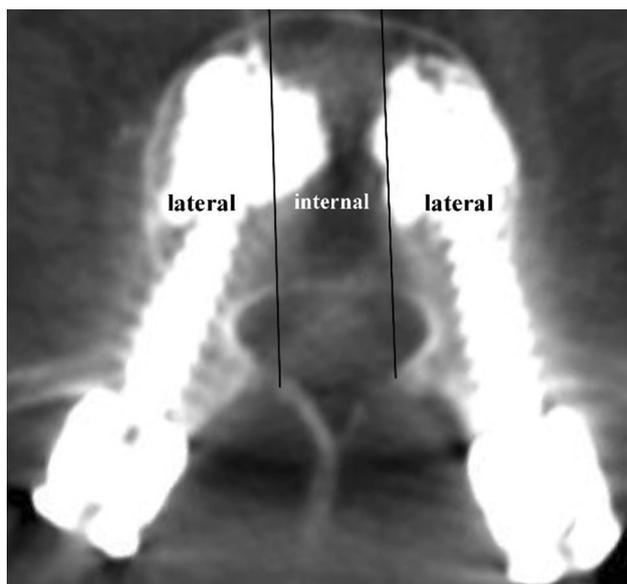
The vertebral body was longitudinally divided into three parts on axial CT scan, and both the tip of screws were placed in the bilateral parts of the vertebral body
